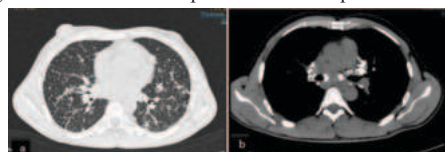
Axial lung window (a) and mediastinal window (b) HRCT section showing multiple centrilobular nodules with fine interlobular septal thickening and calcified hilar lymphnodes. Findings are in favour of silicosis.
